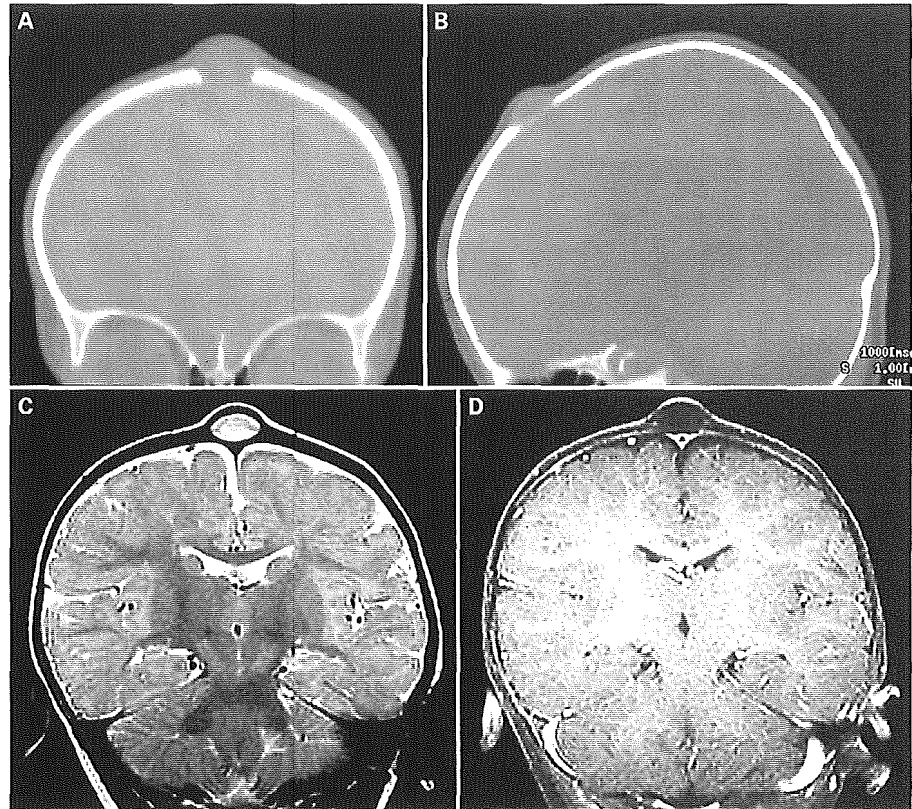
Case 1 at age 9 months. Coronal (A) and sagittal (B) CT demonstrating a mass lesion located on the opened anterior fontanelle. T₂-weighted MRI demonstrating a hyperintense lesion, unconnected to the brain parenchyma or subarachnoid space (C). No enhancement was seen following Gd-DTPA administration (D).
